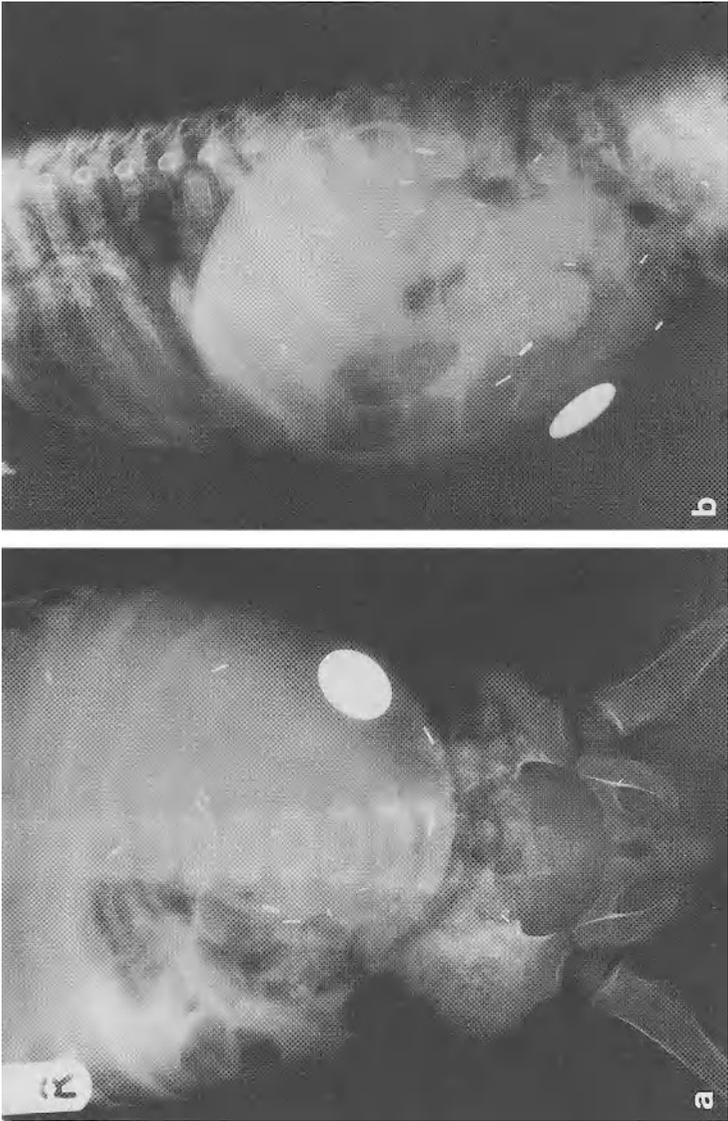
Case 1, a anteroposterior and b lateral plain abdominal radiographs. Status after subtotal tumour excision and left nephrectomy; the contours of the balloon are visible. The metal disk in the left middle abdomen is the filling chamber
